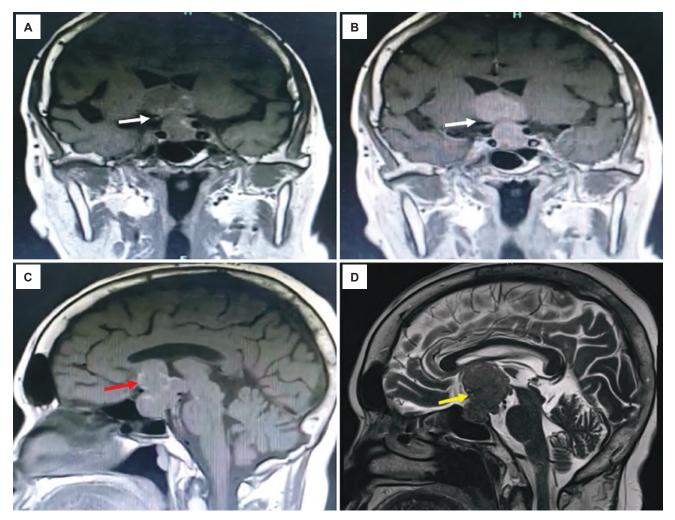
Coronal T1-weighted (A) pre-contrast and (B) post-contrast magnetic resonance imaging of the pituitary showing a homogenously enhancing dumbbell-shaped sellar mass measuring 2.8 cm x 3.6 cm x 3.8 cm. On non-contrast sagittal view, it is (C) T1-hypointense with heterogenous intensity on (D) T2. There is T1 hyperintensity (*red arrow*) and T2 hypointensity (*yellow arrow*) at the peripheral aspect of the mass suggestive of hemorrhage. The posterior bright spot is absent.
